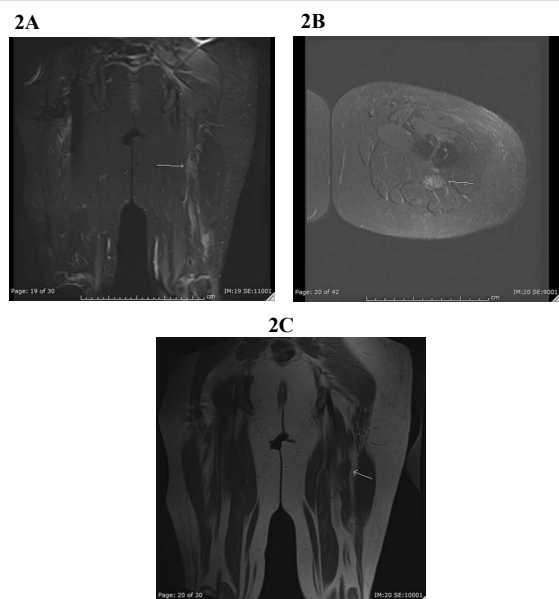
MRI images depicting neuroma formation of sciatic nerve.
